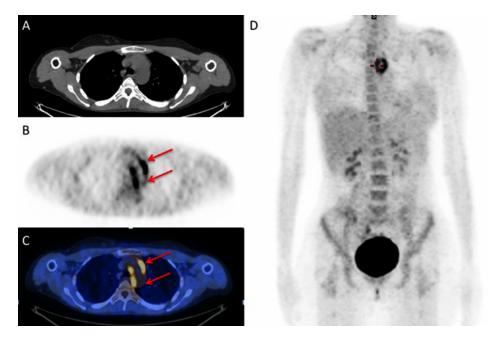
18F-FDG PET/CT transaxial CT (A), PET (B), fusion (C) images show a significantly increased 18F-FDG uptake in a circumferential pattern along the aortic arch (red arrows). MIP images (D) do not show 18F-FDG uptake in lymph nodes and spleen.
